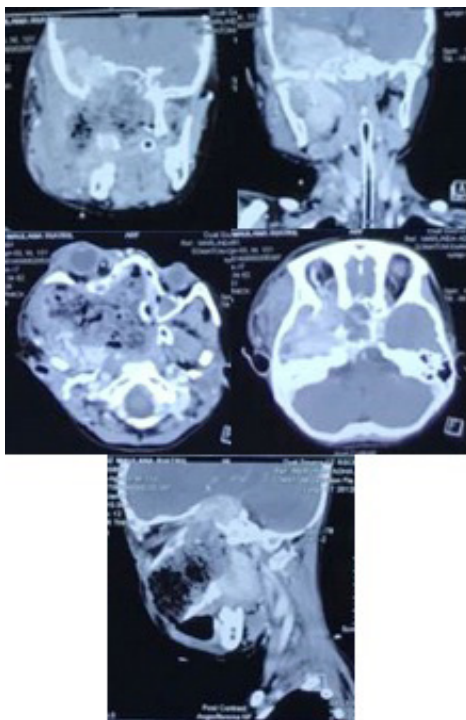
CT scan of nasopharynx post extirpation
